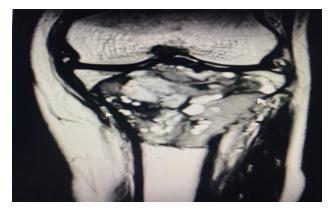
Magnetic resonance imaging of right knee with leg.
